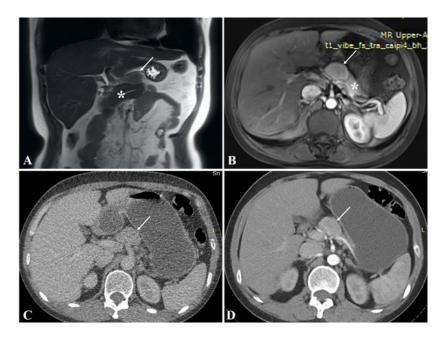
A. Magnetic resonance imaging showed an isointensity lesion(white arrow) located above the pancreas body(\*) was clearly separated from the normal pancreas; B. CE-MRI showed the edge was enhanced in the arterial phase, and the degree of internal enhancement in each phase was lower than that of the pancreatic parenchyma; C. Computed tomography imaging showed that the mixed density nodule(white arrow) located above the pancreatic body was convex and shallowly lobulated, measuring approximately 37 mm×25 mm in maximum dimensions; D. CE-CT showed uneven progressive enhancement, and the degree of enhancement in each stage was lower than that of pancreatic parenchyma.
